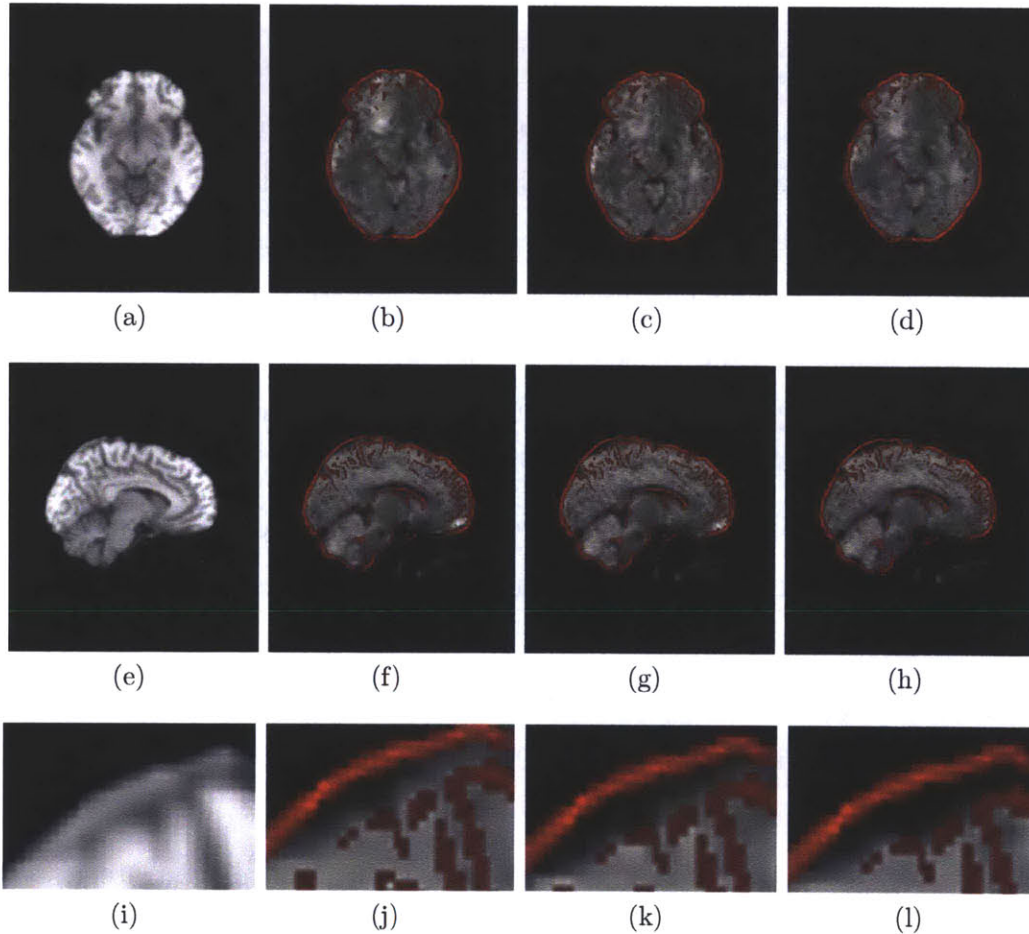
Registration Results for an Axial and Sagittal Slice of a Representative subject. Registration of DWIs following B_0 and eddy current distortion correction using the FF method (d,h) agree well with those obtained by the eddy plus B_0 fieldmap method (c,g) and show improvement over the DWI corrected for B_0 but not eddy distortion (b,f) An edge-strength image of the T1W data is shown in red for visualization of the registration results and a T1-weighted image is shown in (a,e) for reference. A closer view of the results in the sagittal cross-section is shown in row 3.
